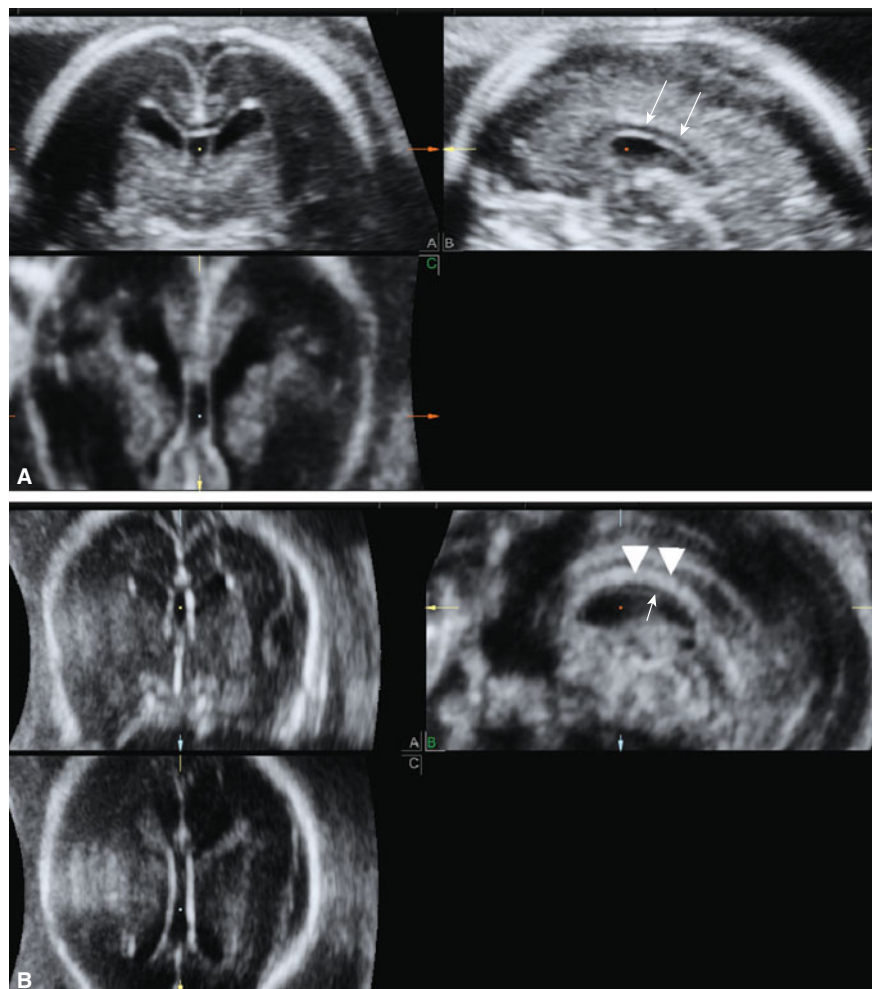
Multipplanar analysis of an ultrasound volume of the fetal head obtained by transabdominal scanning: (A) volume acquired using a sagittal plane and (B) volume acquired using an axial plane. Note the difference of resolution of the CC. When a sagittal plane is used, the CC appears as a thin sonoluent stripe with well-defined echogenic contours (arrows). When an axial plane is used, the CC is not easily differentiated from the cavum septi pellucidi. Sometimes a thin echogenic contour that separates it from the underlying CSP (thin arrow) and a comma-shaped echogenic structure overlying both the CC and CSP (arrow head) are seen, as demonstrated in this case.
